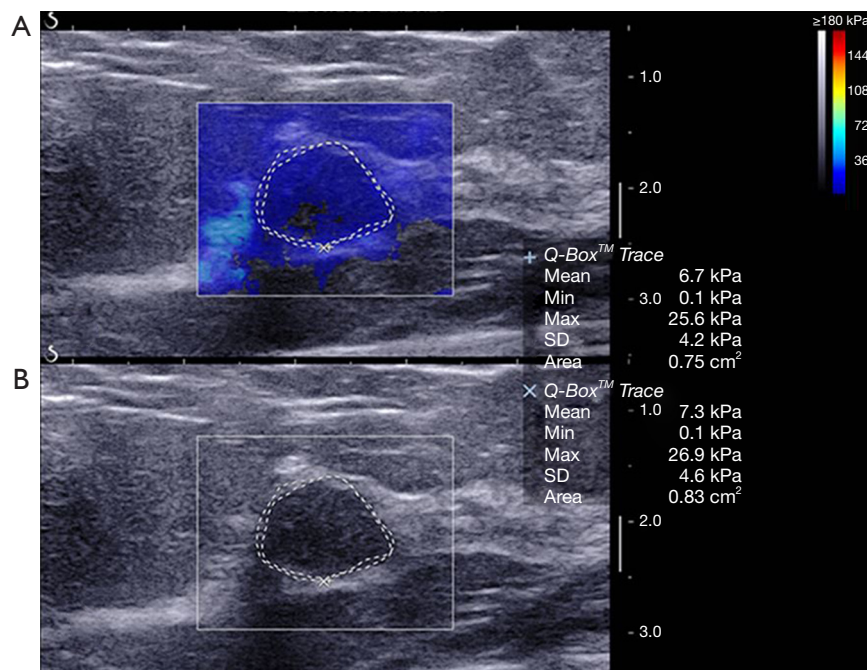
A 54-year-old woman with a 14 mm fibroadenoma. The US shows (B) a circumscribed, wider than taller, hypoechoic nodule assessed as BI-RADS category 3, while the corresponding SWE (A) shows an oval homogeneous mass with blue color and Emax of 26.9 kPa. SD, standard deviation; US, ultrasound; BI-RADS, Breast Imaging-Reporting and Data System; SWE, shear-wave elastography; Emax, maximum elasticity.
